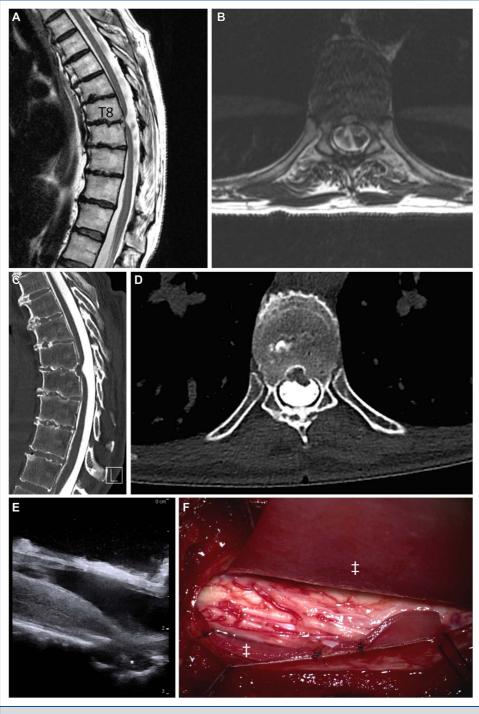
MRI of a 50-year-old female patient who suffered from a spinal cord hernia at T8/9. A, Sagittal T2-MRI showing the spinal cord herniated into the intervertebral disk. B, Corresponding axial T2-MRI. Computed tomography myelography showing the spinal cord hernia from C, sagittal and D, axial. Intraoperative longitudinal ultrasound E, shows the spinal cord herniated through the dura. *Herniated spinal cord. F, Intraoperative image showing the circumferential allograft patch, which is partially sutured and glued, ‡Circumferential dural allograft patch.
